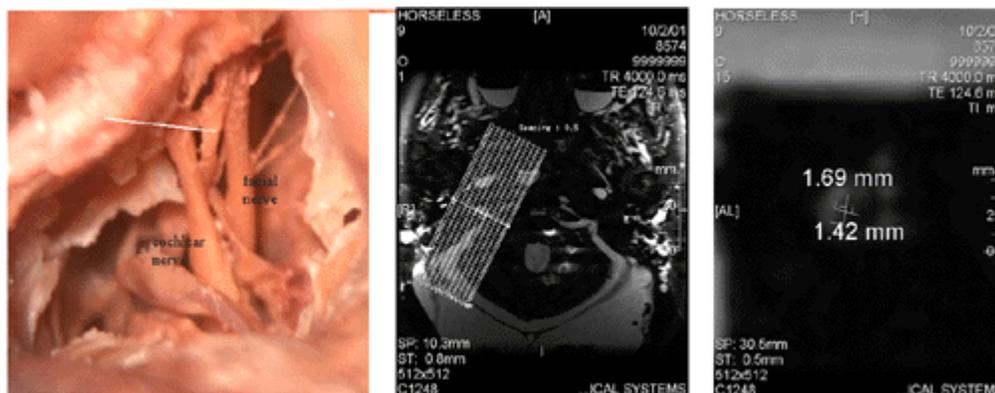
left: dissected human cochlear aperture. Center: low resolution MRI image of temporal bone. Right: High resolution image of cochlear nerve
